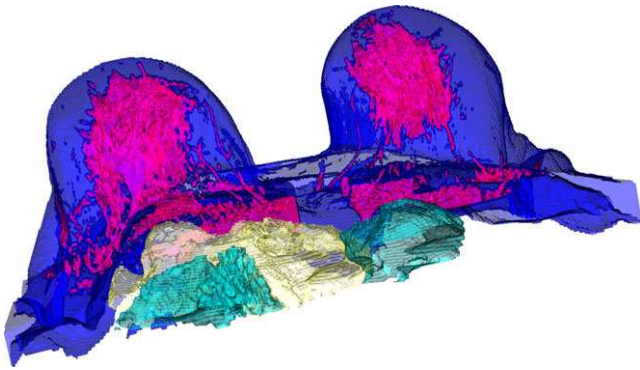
Labeled regions from T1 precontrast MR image. The internal organs were delineated using a probabilistic atlas approach while a slicewise region growing algorithm was used to segment the background. The breast tissues were segmented using an expectation–maximization algorithm, obtaining: the adipose tissue in blue, the glandular tissue in purple, and the internal organs, such as the pectoral muscle, the heart, and the lungs, in dark blue, yellow, and green, respectively. The visualization was carried out using the software MeVisLabTM (Section 6.D).
